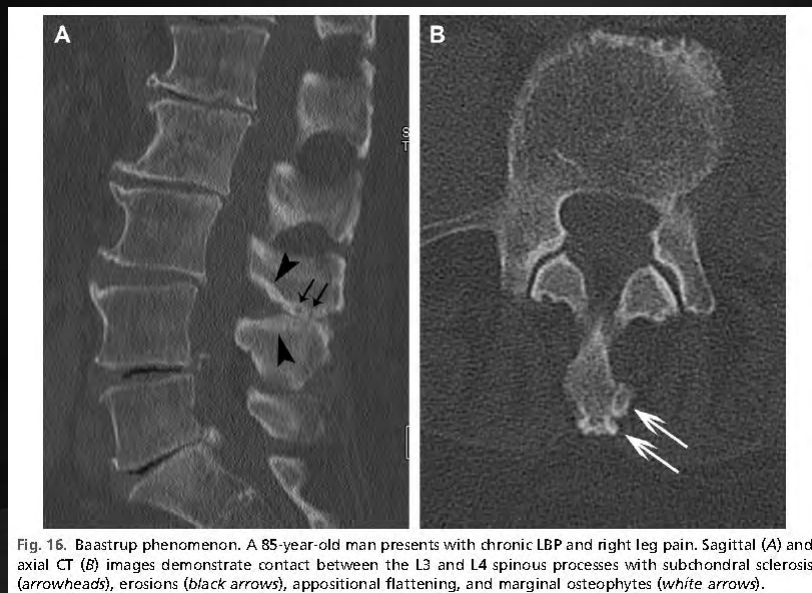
Bastrup phenomenon. A 85-year-old man presents with chronic LBP and right leg pain. Sagittal (A) and axial CT (B) images demonstrate contact between the L3 and L4 spinous processes with subchondral sclerosis (arrowheads), erosions (black arrows), appositional flattening, and marginal osteophytes (white arrows).
